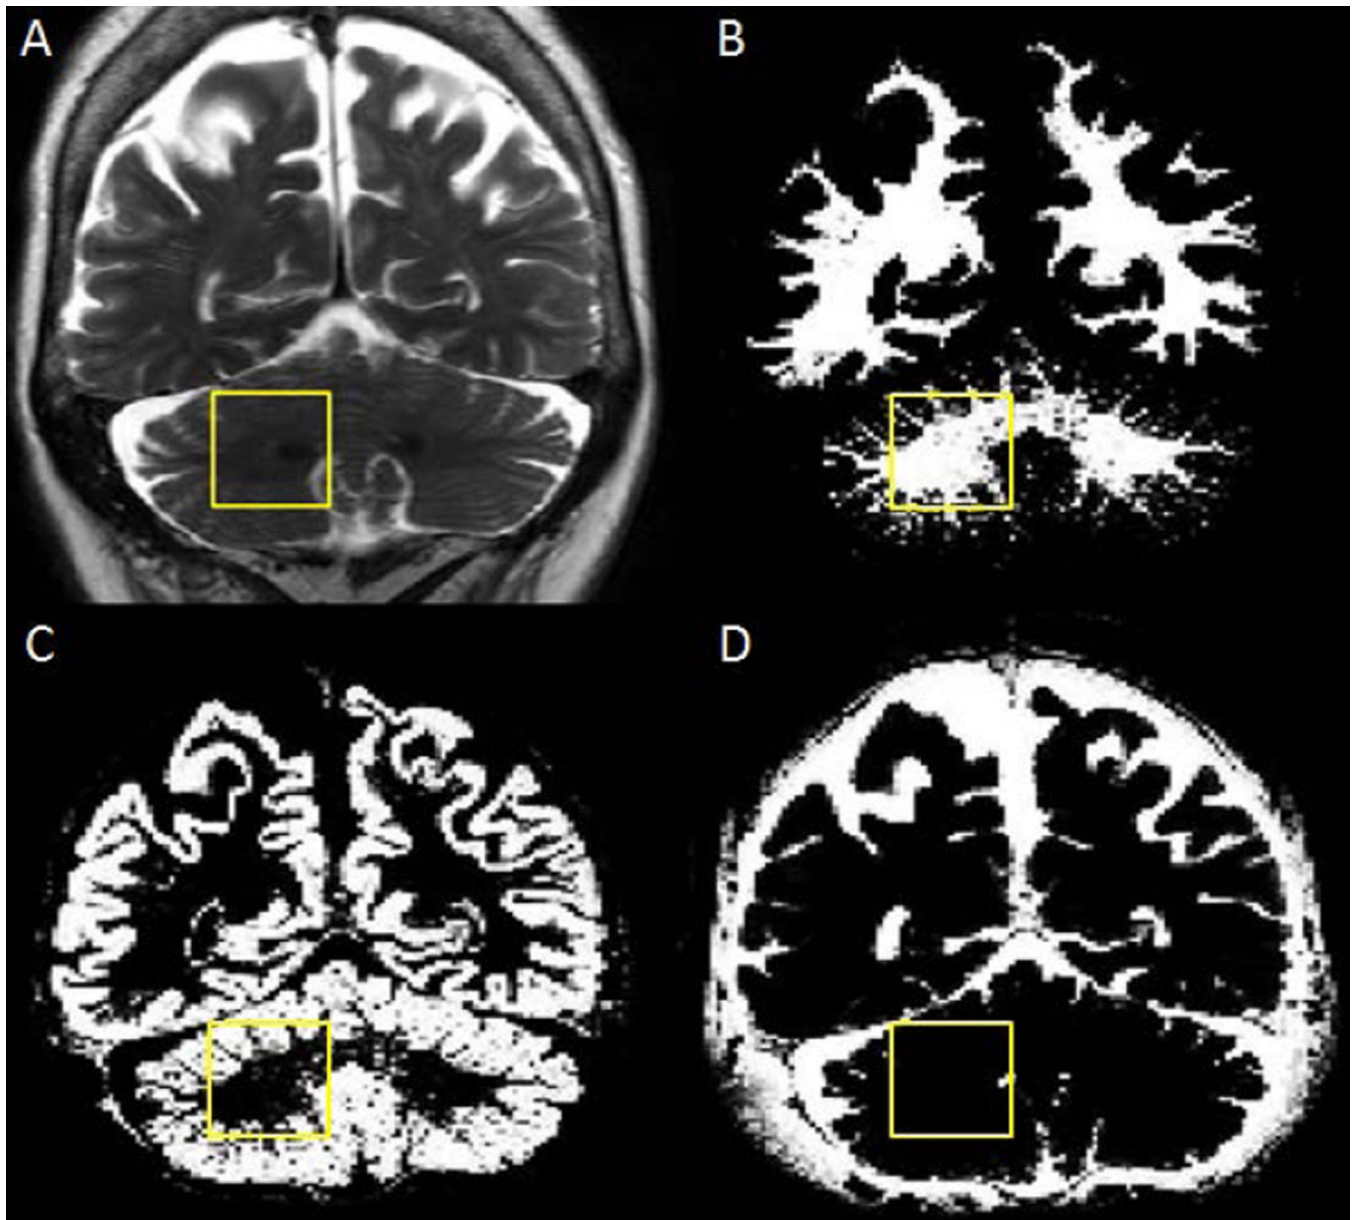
Representative tissue segmentation of the cerebellum: (A) T2-weighted image showing the right cerebellar dentate VOI from Figure 1. (B), (C) and (D) show white matter, gray matter and cerebrospinal fluid maps of the same slice, respectively.
